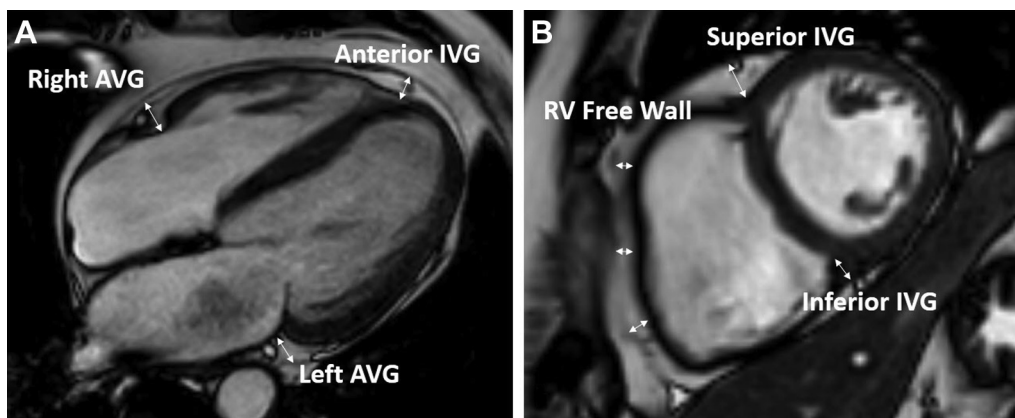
Examples of echocardiographic measurement of epicardial adipose tissue (EAT) thickness on cardiac magnetic resonance imaging (CMR) at different locations, including right and left atrioventricular grooves (AVGs), as well as anterior, inferior, and superior interventricular grooves (IVGs), and also right ventricular (RV) free wall. A: True fast imaging with steady-state precession (TrueFISP) image of horizontal long-axis view in end-diastole. B: TrueFISP image of short-axis view in end-diastole. The EAT thickness of RV free wall was recorded through averaging the measurement of 3 different levels.
